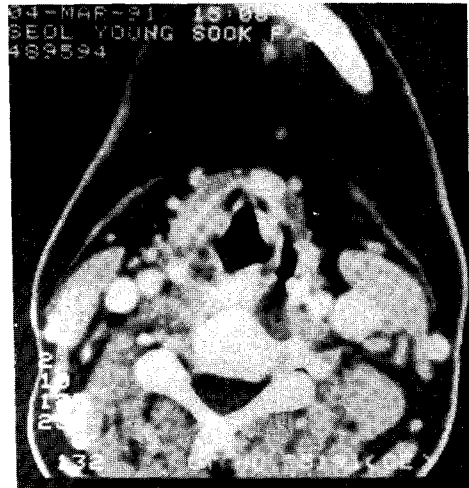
The neck CT scan demonstrated a 1 cm sized mass on the right true vocal cord.
